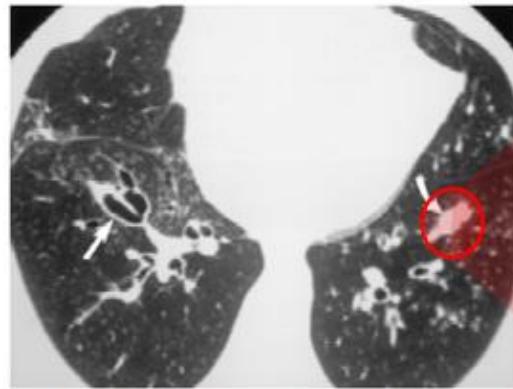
Axial high resolution CT image (window width 1,000, level -700) reveals central bronchiectasis (straight arrow) and mucoid impaction (curved arrow), characteristic of allergic bronchitis.
